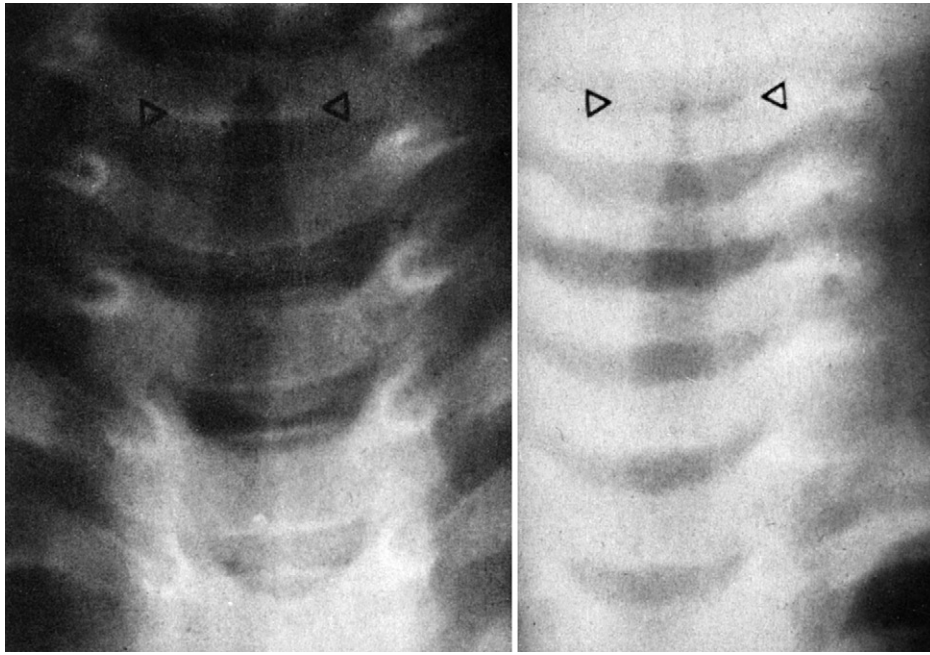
Anteroposterior radiograph of the neck. *Left*, A normal tracheal air column (between the arrows). *Right*, Trachea narrowed by laryngotracheobronchitis.
